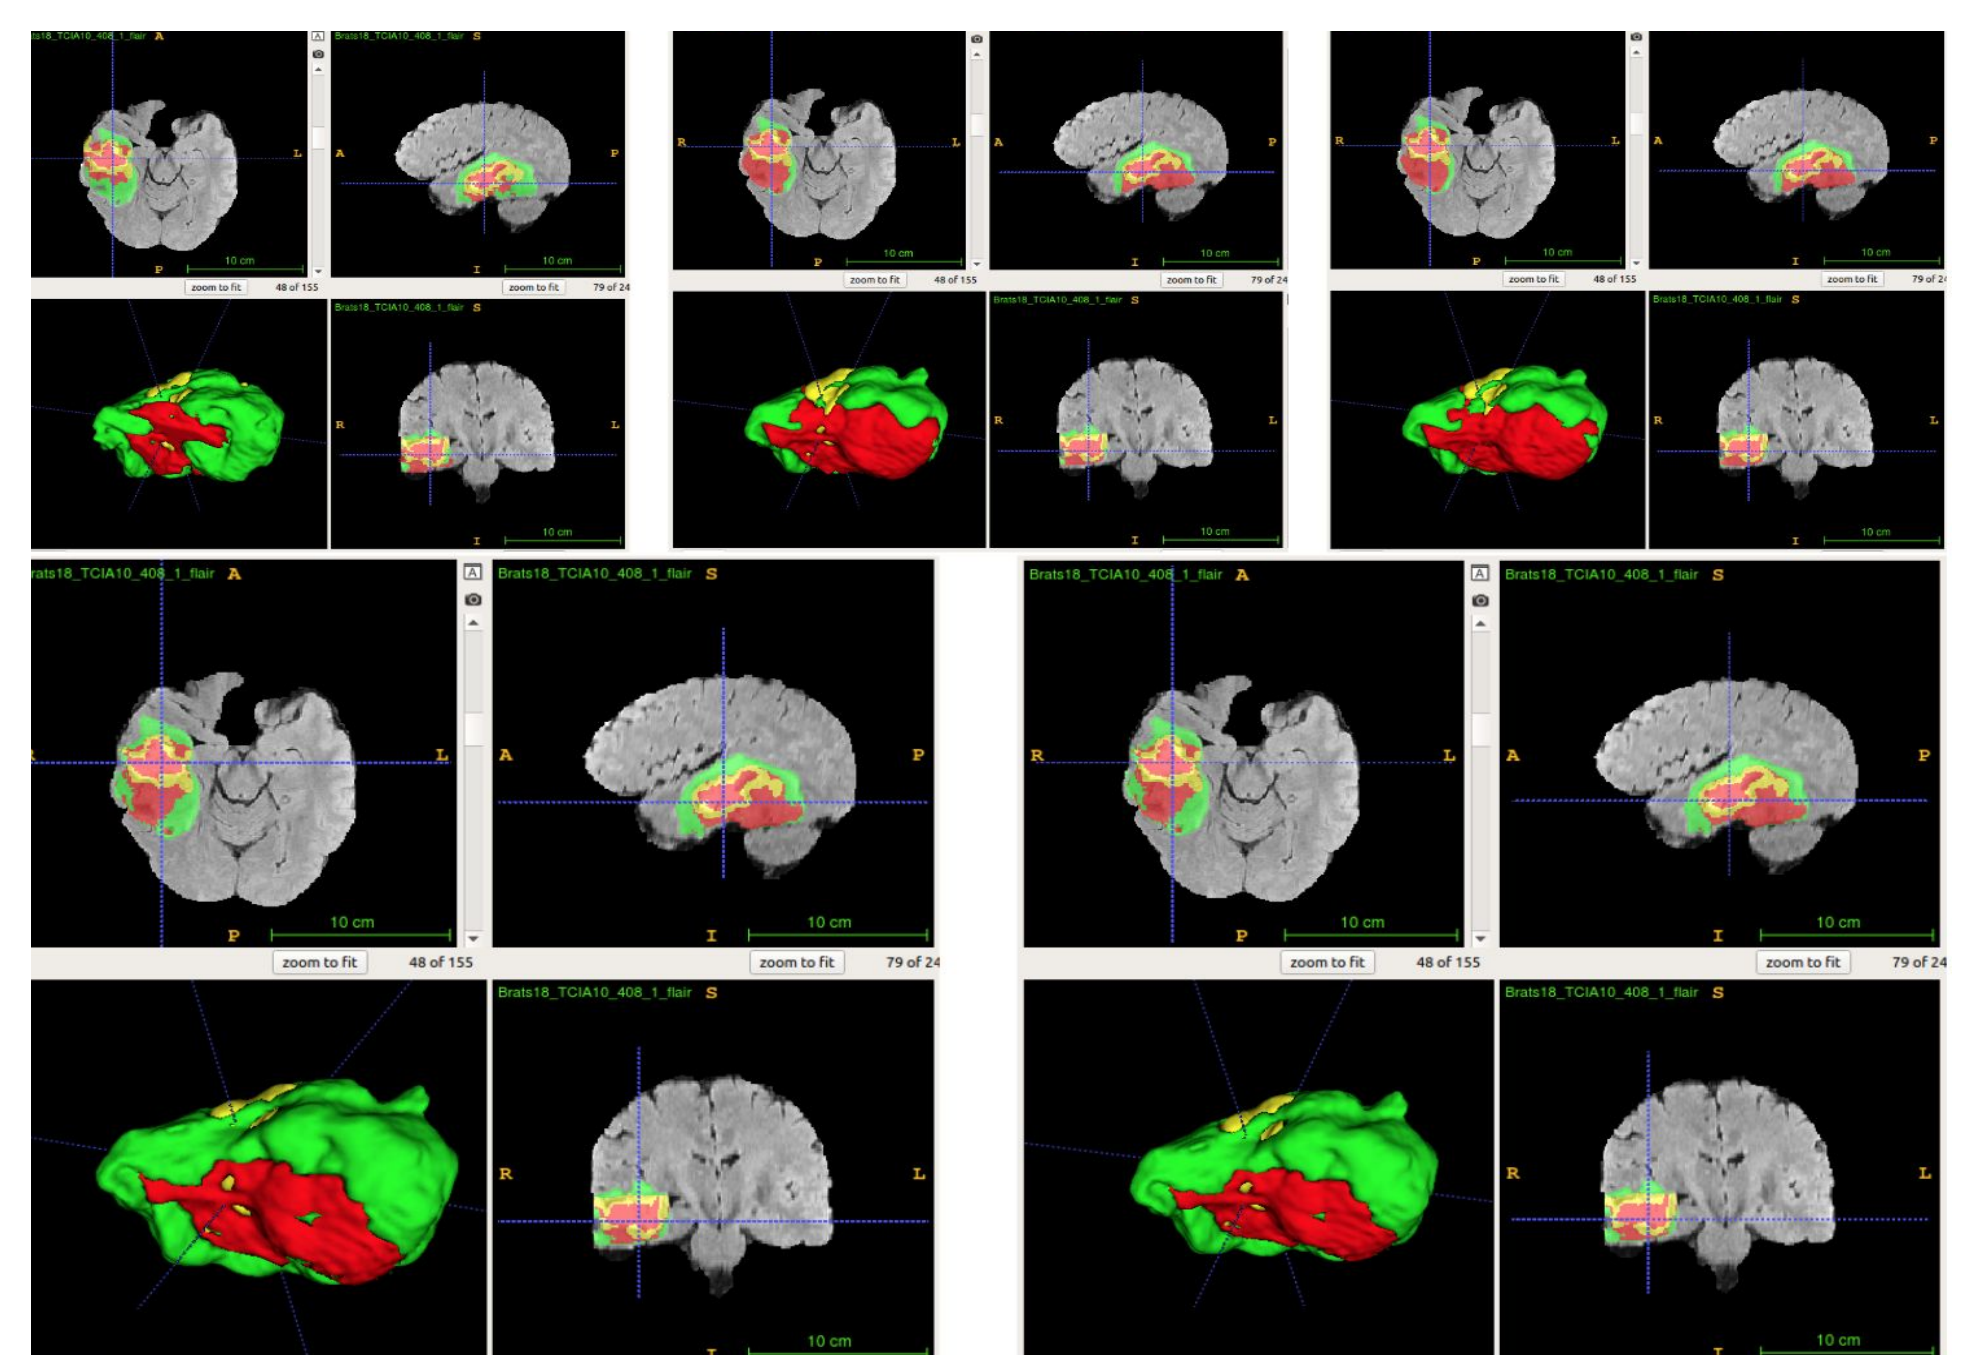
Examples of predictions from different ensemble methods. The top left image shows the ground-truth lesion mask, and the top middle image shows the predictions using the arithmetic mean. The top right image shows the prediction using a two-level multi-class classification (TLMC) method. The bottom left image shows the prediction using a two-level binary classification (TLBC) method, and the bottom right image shows the prediction using a two-level fusion classification (TLFC) method. Red: enhancing tumor, yellow: necrosis & non-enhancing tumor, and green: edema. ITK-SNAP (Fedorov et al., 2012) is used to visualize the MR images and lesion masks.
